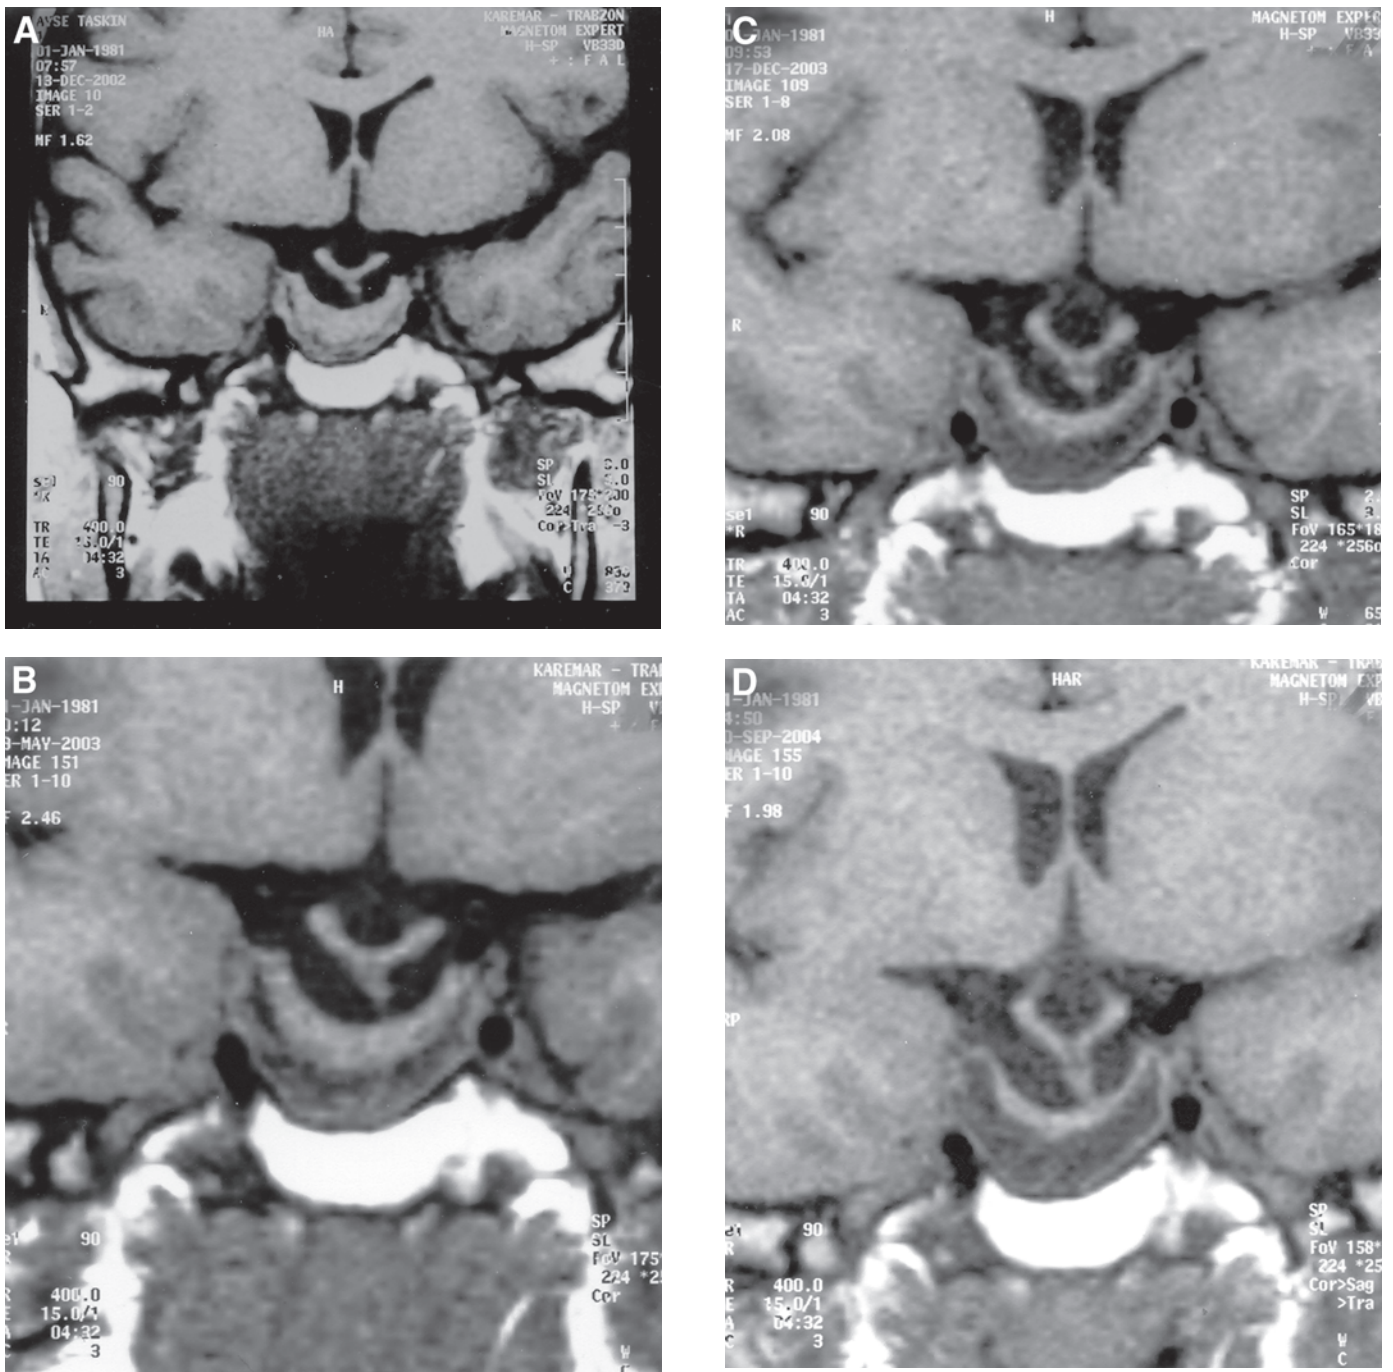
Nonenhanced T1-weighted coronal MR images obtained at the level of pituitary stalk. MR scan shows that octreotide-LAR treatment for 6 wk resulted in a marked tumor size reduction (A). Crescent-shaped hypointense area which consisted of necrosis; 6.5 mo after treatment (B), 13.5 mo after treatment (C), and approx 2 yr after treatment (D). MR image shows progressive increase in the necrotic area.
